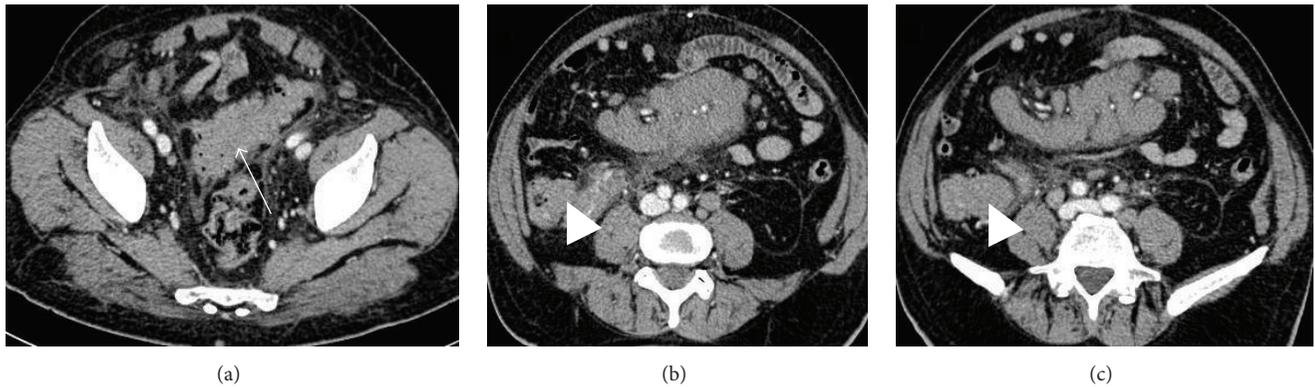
Abdominal CT scan of ileal and sigmoid lymphoma in a 78-year-old male. Axial CT scan in the portal venous phase shows a non-Hodgkin lymphoma seen as abnormal circumferential bowel thickening of the sigmoid colon ((a) arrow) and of the last ileal loop ((b) and (c) arrowheads). Enhanced lymphomatous small bowel loops (b) represent the halves of a sandwich, enveloping enhanced vessels (the sandwich filling). The patient underwent chemotherapy with marked reduction of the thickening at the follow-up CT scan.
